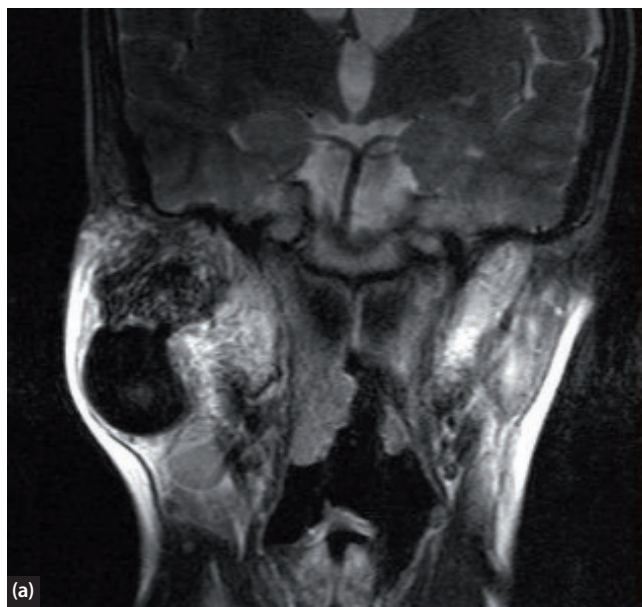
Large right arteriovenous malformation in a 15-year-old male. (a) Coronal T2-weighted MRI, demonstrating a large flow void (the nidus), and numerous interconnections with other vessels. (b) Angiographic appearance at the time of embolization. The nidus is clearly seen, along with multiple arteriovenous anastomoses with intra- and extracranial vessels.
